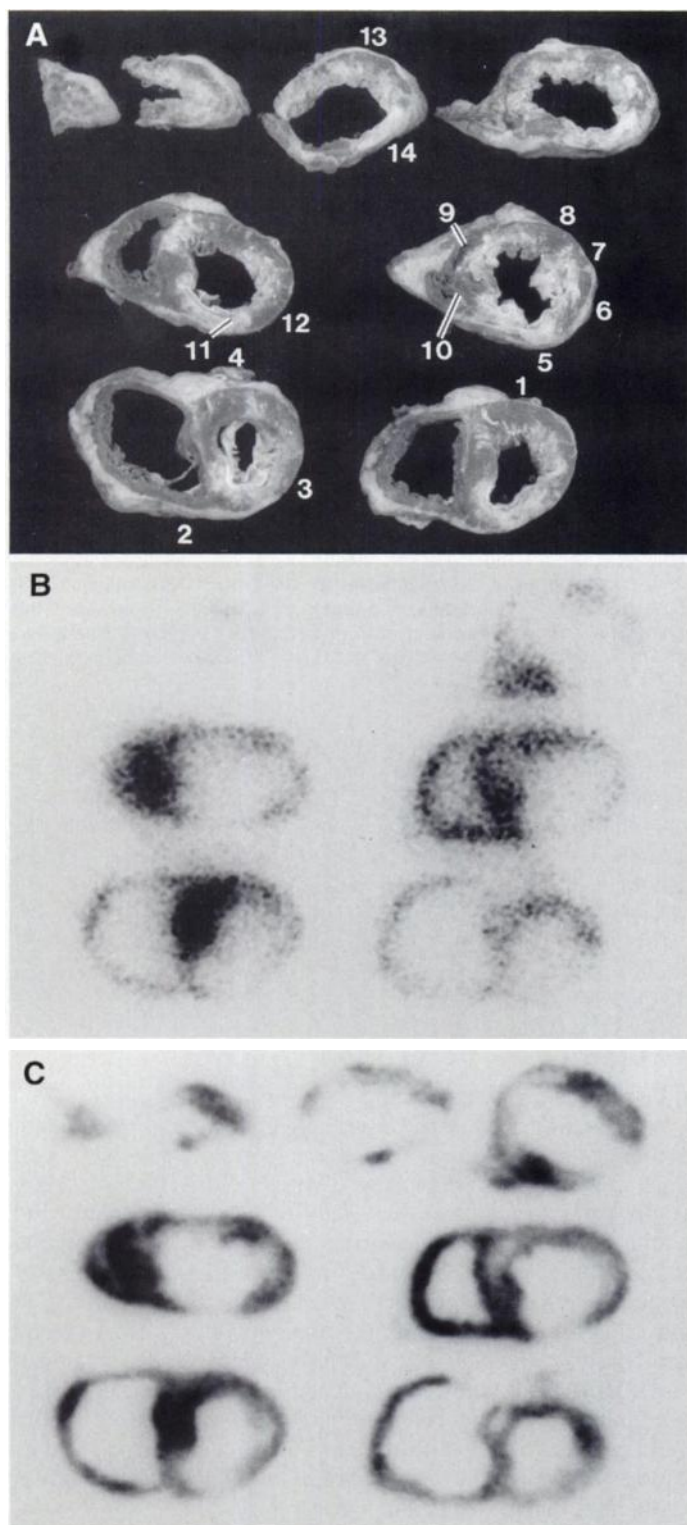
Explanted heart cut into 1-cm thick slices parallel to the atrioventricular sulcus. (A) Locations of tissue sampling. Macroscopic findings: transmural scar posterolateral, rest of myocardium predominantly viable with endocardial and patchy interstitial fibrosis. Dual-isotope scintigraphies with (B) [^{131}I]PHIPA 3-10 and (C) $^{99\text{m}}\text{Tc}$ -sestamibi.
